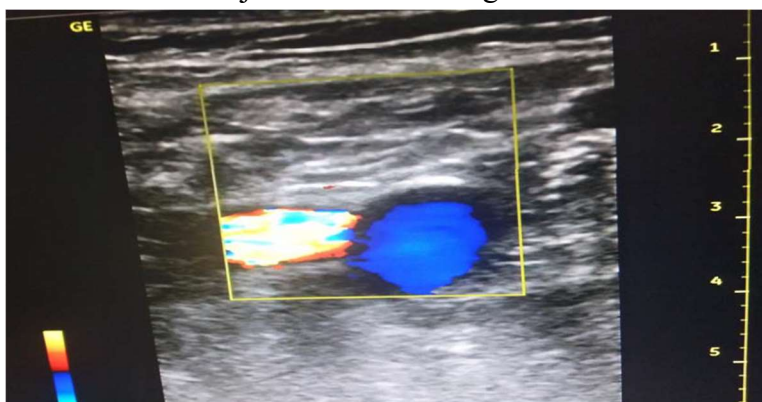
Ultrasound examination of the femoral artery and vein
